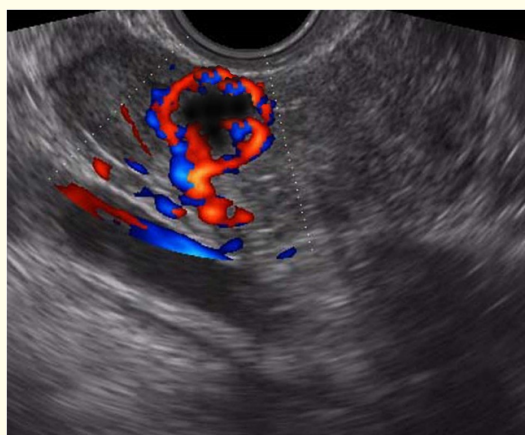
Transvaginal color Doppler ovarian view of a 28-year-old fertile female next day of ovulation. On the periphery of the corpus luteum a colored corolla is visualized.
